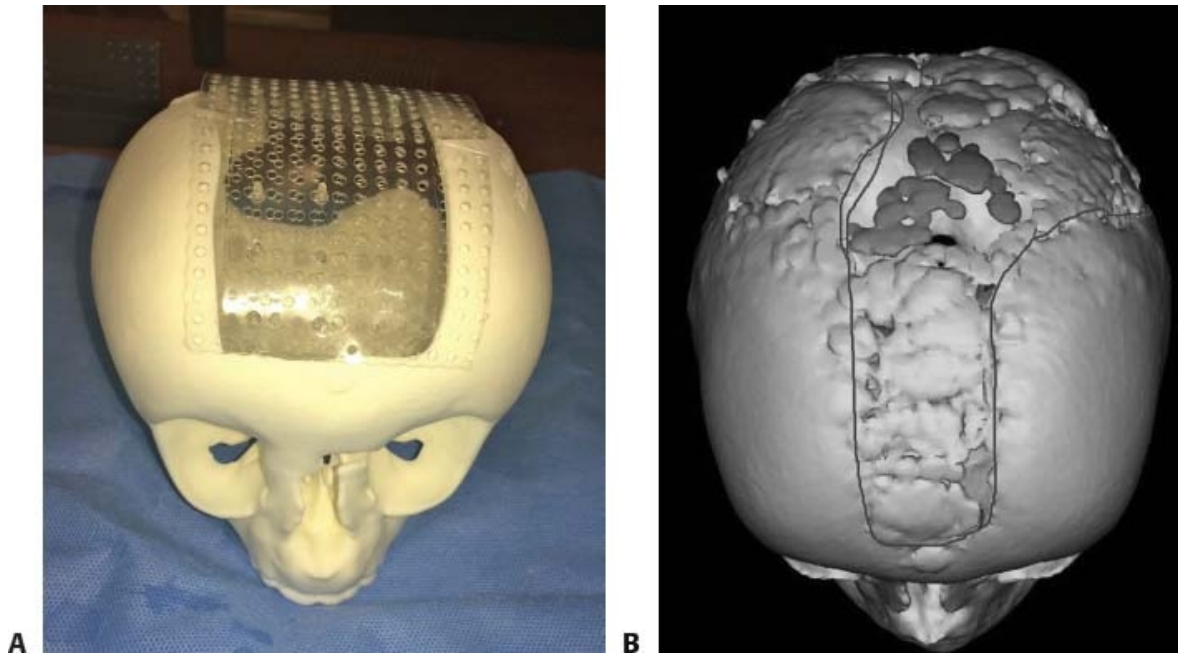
• Large pediatric cranial vault defect involving the frontal, parietal, and occipital regions. A. 3D model created for reconstructive planning using bilaminar resorbable plate construct with intervening BMP-2. B. 3D CT scan 6 months after surgery demonstrates healing at the periphery and centrally. The patient demonstrated complete calvarial healing at 1 year.
